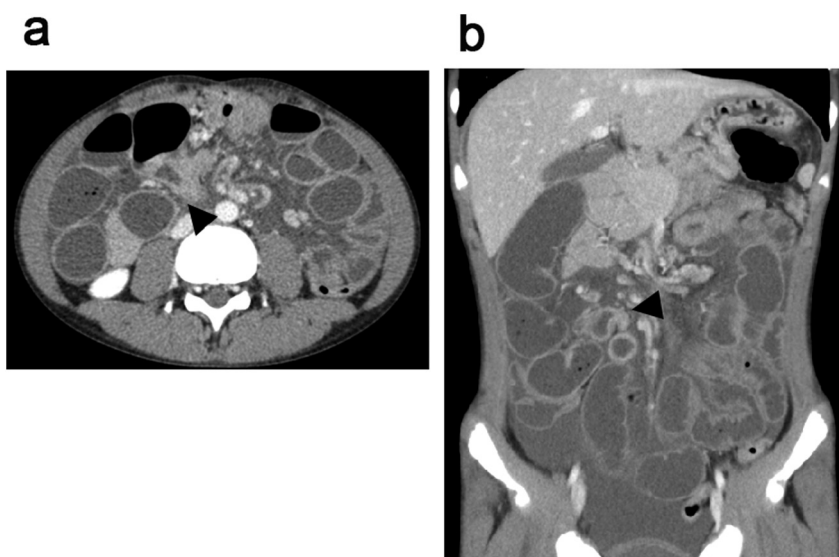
Findings of axial (a) and coronal (b) views on contrast computed tomography (CT). The images demonstrate closed-loop obstruction (black arrowhead) at the navel level of the abdomen and ascites in the pelvic cavity.
